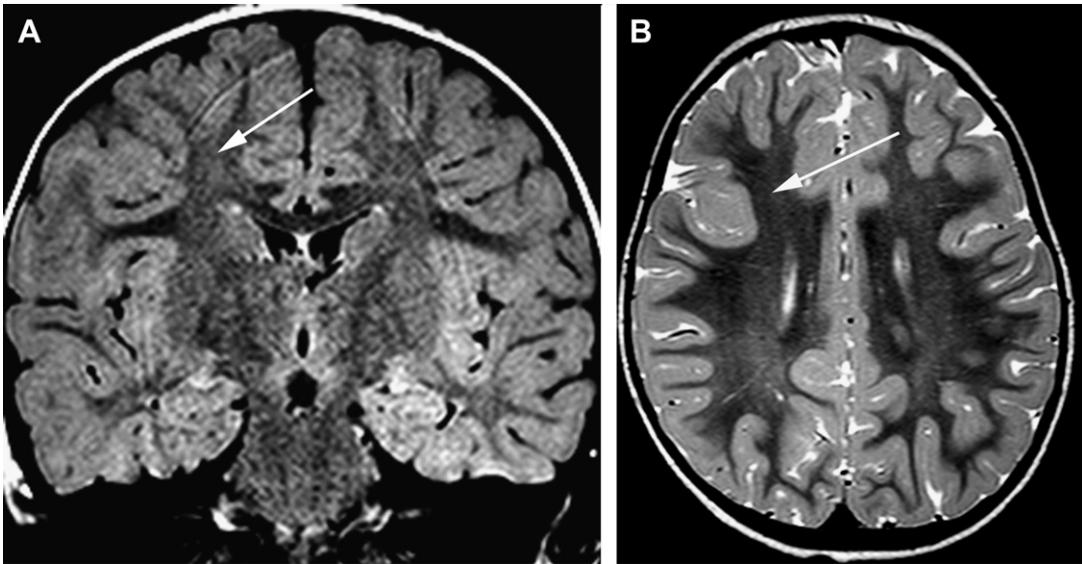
Cortical dysplasia with astrocytic inclusion of filamin A. (A, B) Coronal FLAIR and axial T2 demonstrate an abnormal deep sulcation in the right lateral frontal lobe (arrow). Pathology demonstrated a dysplastic cortex and white matter, with astrocytic inclusions corresponding to intracellular accumulation of filamin A.
